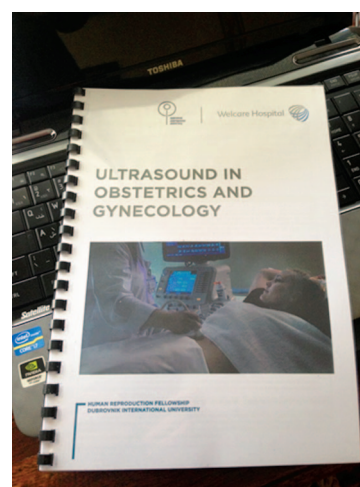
Curriculum of ultrasound obstetrics and gynecology
